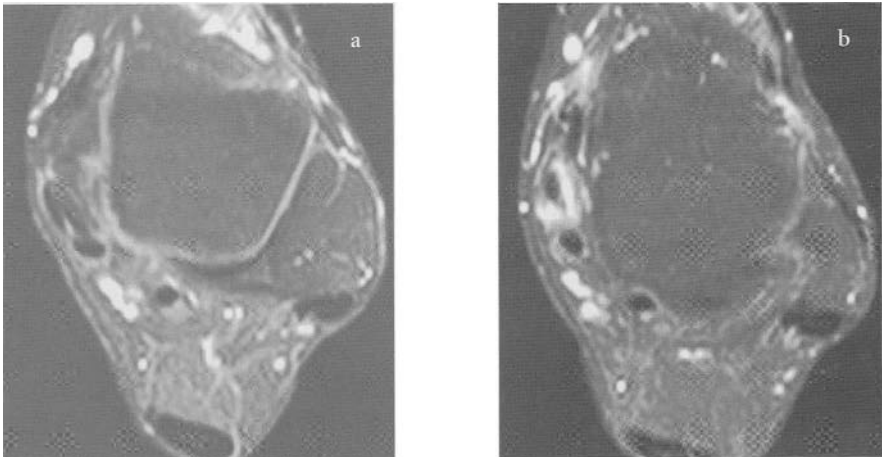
Same patient. MRI, T1 fat-sat gadolinium (2002). The tendinopathy of the left ptt has worsened: there is a longitudinal retromalleolar fissure (fig. a) and a stage 2 tendinopathy under medial malleoli (fig. b).
